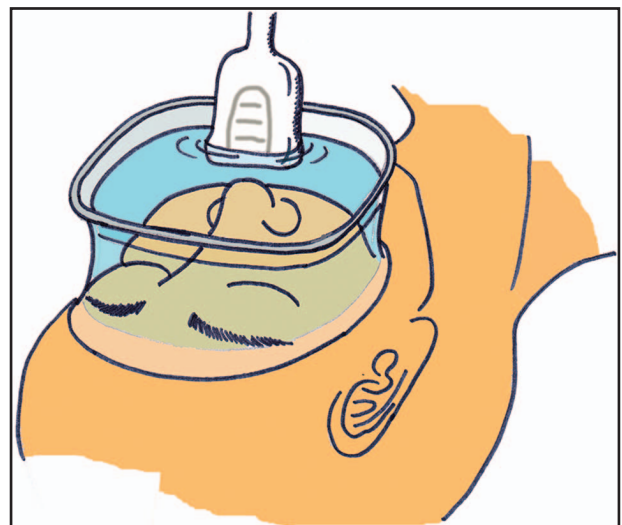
Saline was used as coupling medium for ultrasonography. The outer frame of a snorkeling mask made of thermoplastic elastomer was used to keep saline on the face. To prevent saline from entering the nasal cavity, the nostrils were sealed with medical tape.
